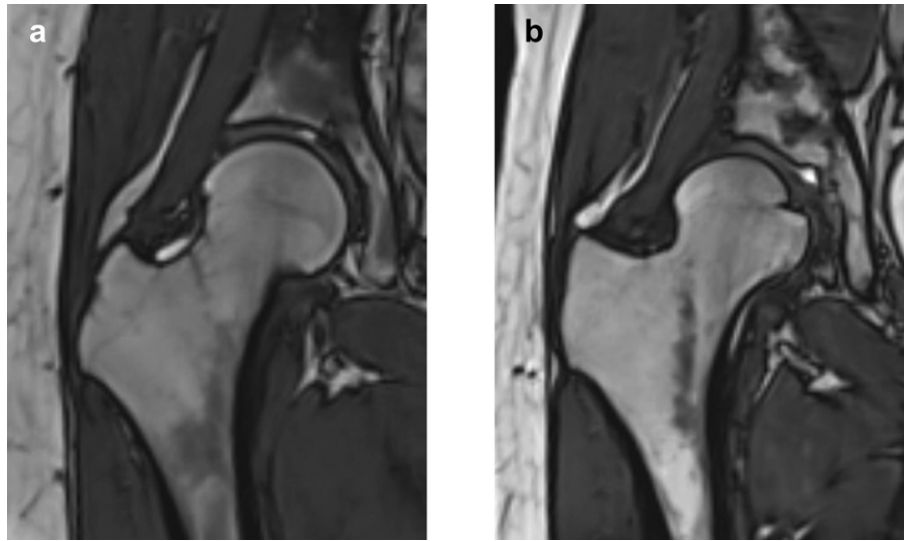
Representative magnetic resonance images using TrueFISP (TR/TE, 4.96/2.13 ms; flip angle, 28°; section thickness, 1.0 mm; in-plane resolution, 1.0 mm; matrix, 384 × 384; imaging direction, coronal). (a) A right normal female hip. (b) A right dysplastic hip.
